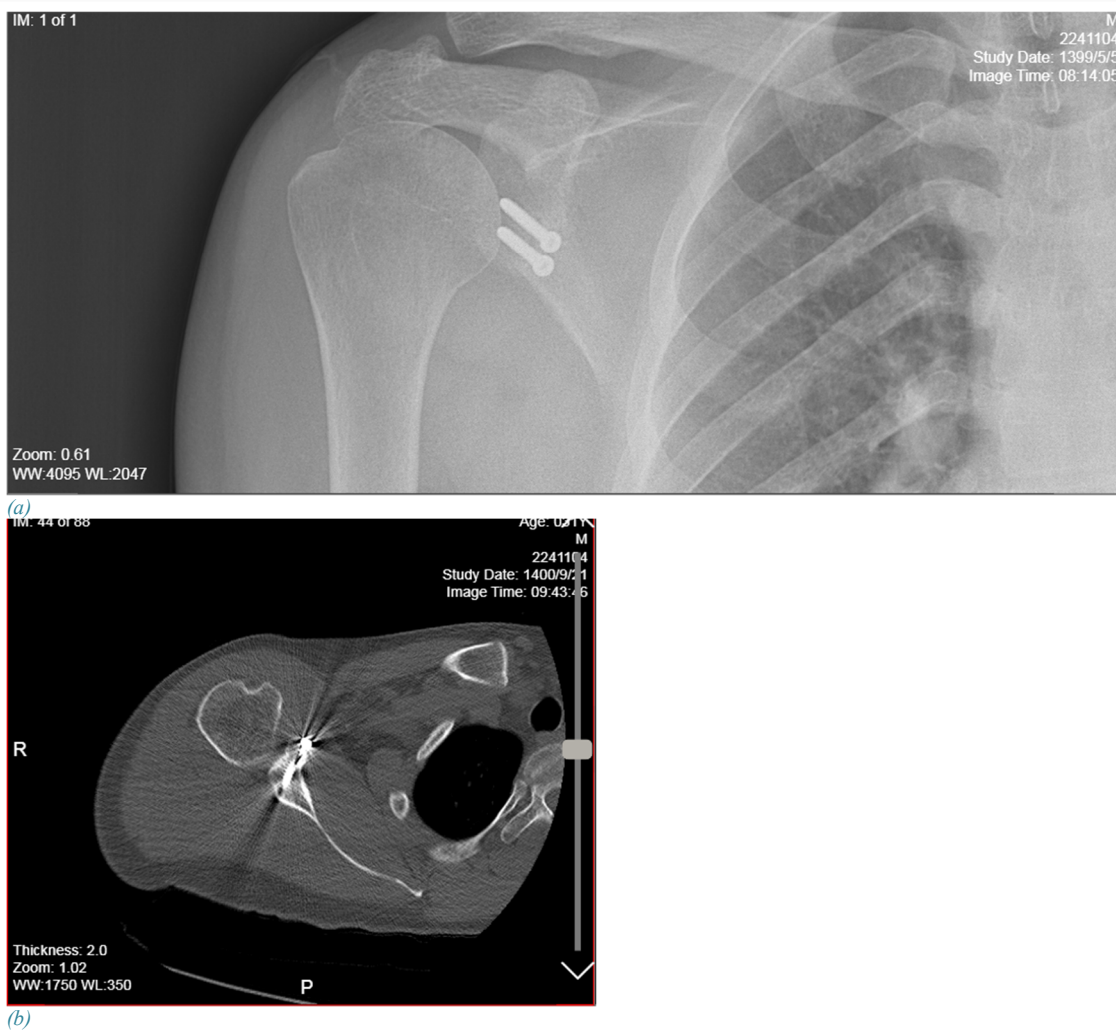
(a) Postoperative anteroposterior radiograph and (b) axial view computed tomography scan showing the graft union
